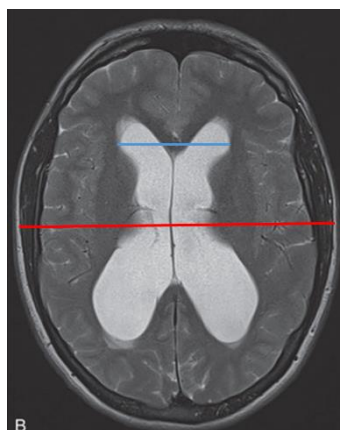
(B) Axial T2 sequence MRI scan of a patient showing ventriculomegaly (Toma, 2018). Copyright 2018 by Elsevier.
